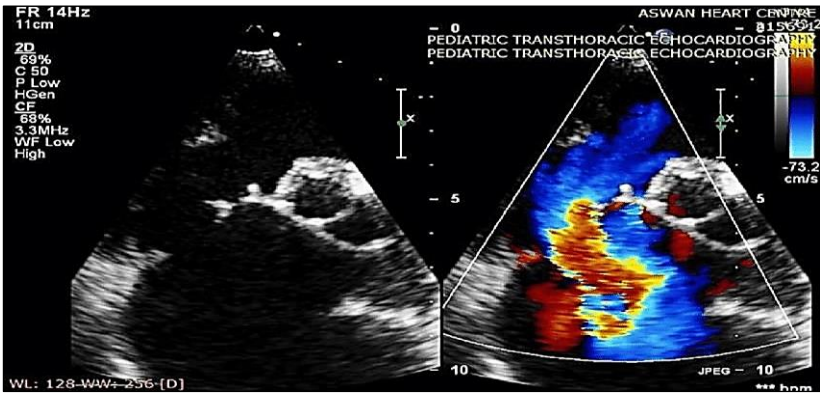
Tricuspid regurgitation echocardiography
